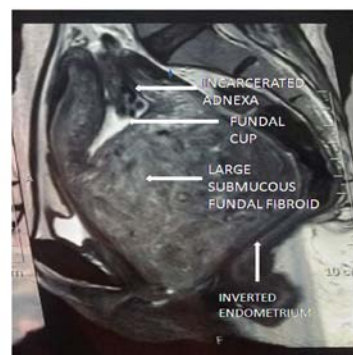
MRI showing large submucous fundal fibroid causing inversion of the uterus
